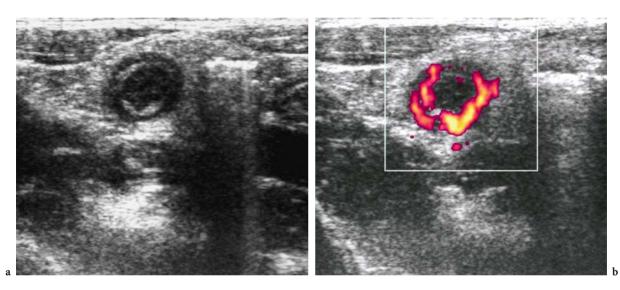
Acute appendicitis on color Doppler US. a B-mode US axial scan showing a two-ring-pattern appendicitis. b Color Doppler demonstrates hyperemia of the appendiceal wall manifested as an increased circumferential color flow, mostly in the submucosal layer
